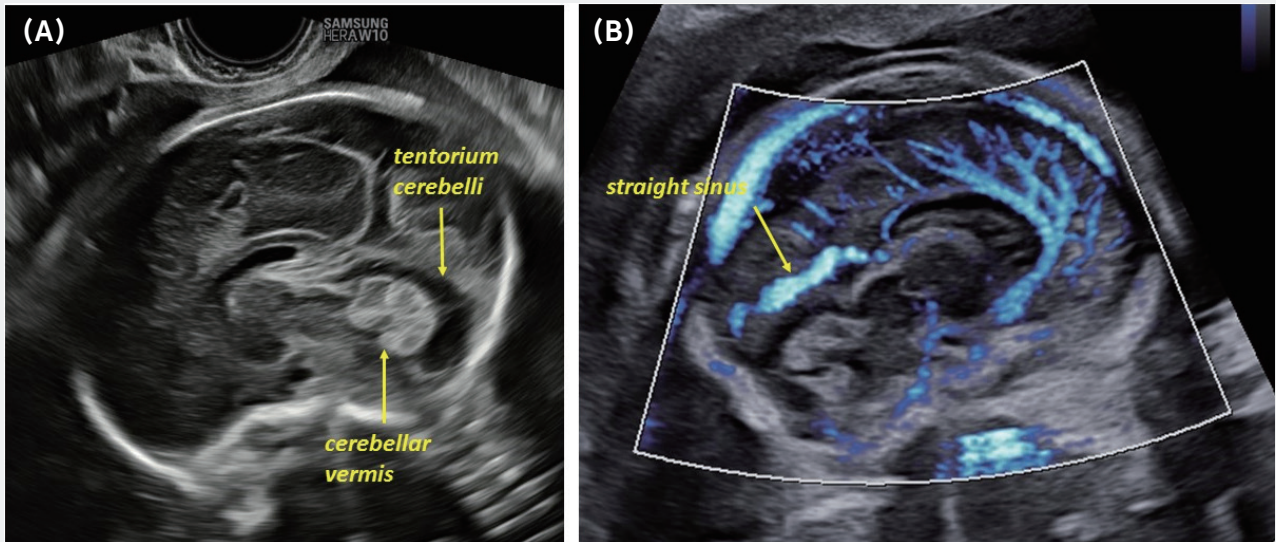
Ultrasound imaging of the fetal central nervous system on transvaginal ultrasound on the midsagittal plane through the sagittal suture. (A) Visualization of the cerebellar vermis and the tentorium cerebelli on two-dimensional ultrasound. (B) Visualization of the straight sinus with MV-Flow™ and LumiFlow™.
